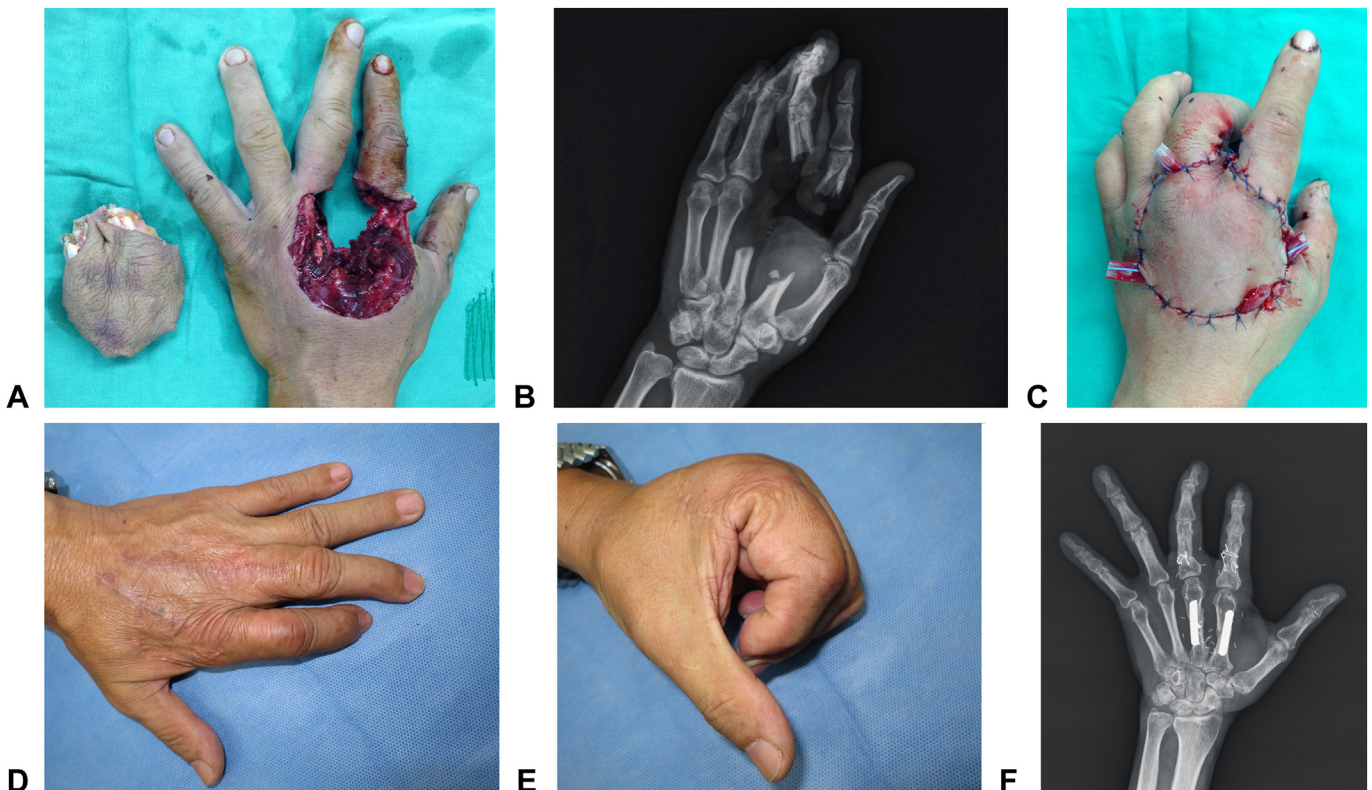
A Left hand punch injury with partial palm complete amputation. B Preoperative X-ray revealed bone and MCP joint defect on second and third rays. C Orthotopic replantation was performed, metacarpals were fixed with plates, and the phalangeal bones were repaired with intraosseous wires. D–F At the 2-year follow-up, the hand exhibited satisfactory function.
